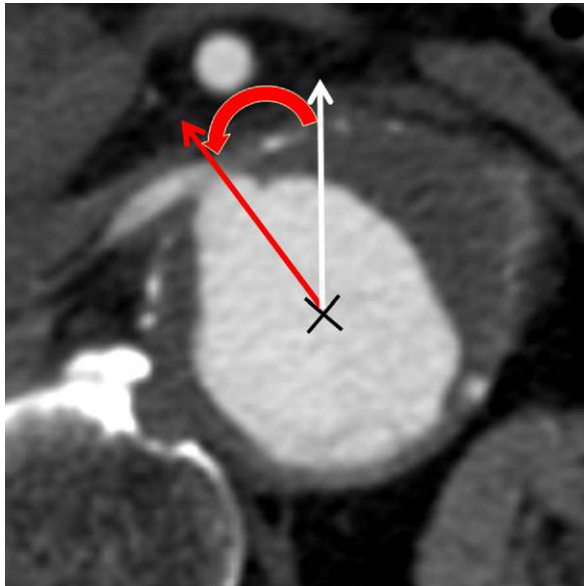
A transaxial representation of computed tomographic angiography (CTA), showing measurement of a planned cuff orientation (red arrow) relative to a line (white arrow) through the centerline of the aortic lumen.
